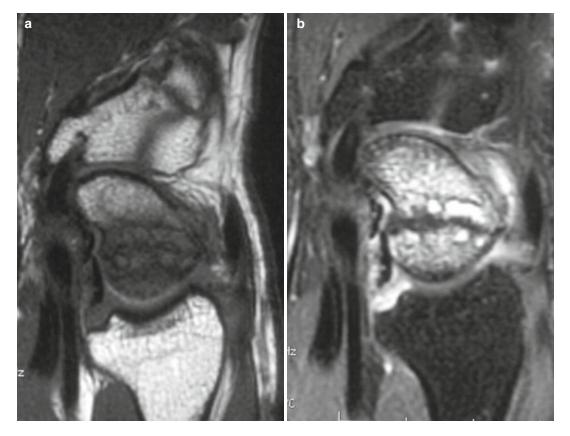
(a) MRI with signal loss in T1 imaging (b) MRI with hyperenhancement by use of gadolinium in T2 fat saturated imaging as a sign of compromised blood supply
